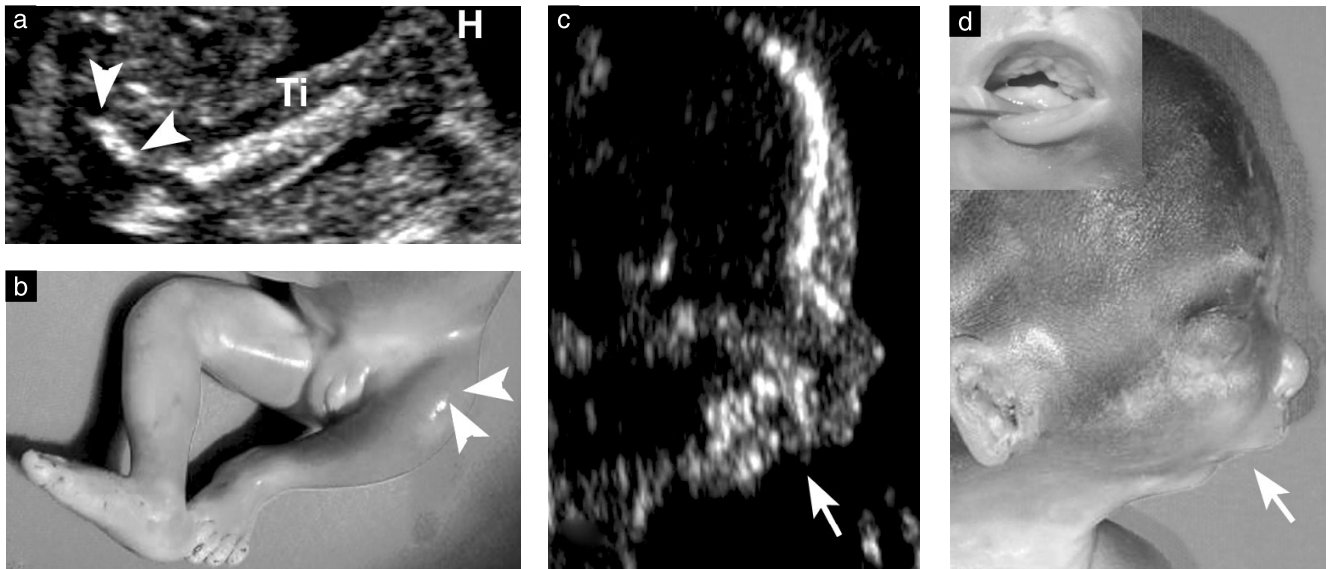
Case 1 at 21 weeks' gestation. (a, b) Ultrasound images showing symmetrical femoral hypoplasia; the femur is completely absent on the left side (a; ??) and severely hypoplastic on the right (b; arrowheads and F). (c) Confirmation of the diagnosis at necropsy; note also the talipes. (d) Axial view of the fetal head showing the wide cleft of lip and palate (arrow). (e) Confirmation of the diagnosis at necropsy; note also the additional subtle facial features, including upslanting palpebral fissures, long philtrum and thin upper lip.
